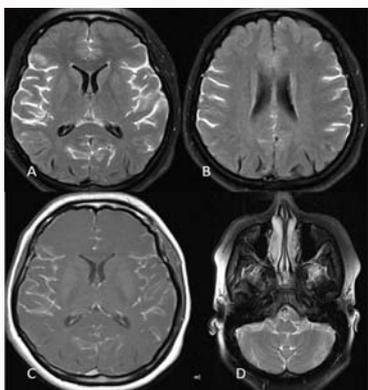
A and B shows sulcal FLAIR hyper intensity, C shows T1W post contrast with intense meningeal enhancement and T2W image in D shows reduced size of the cyst.
